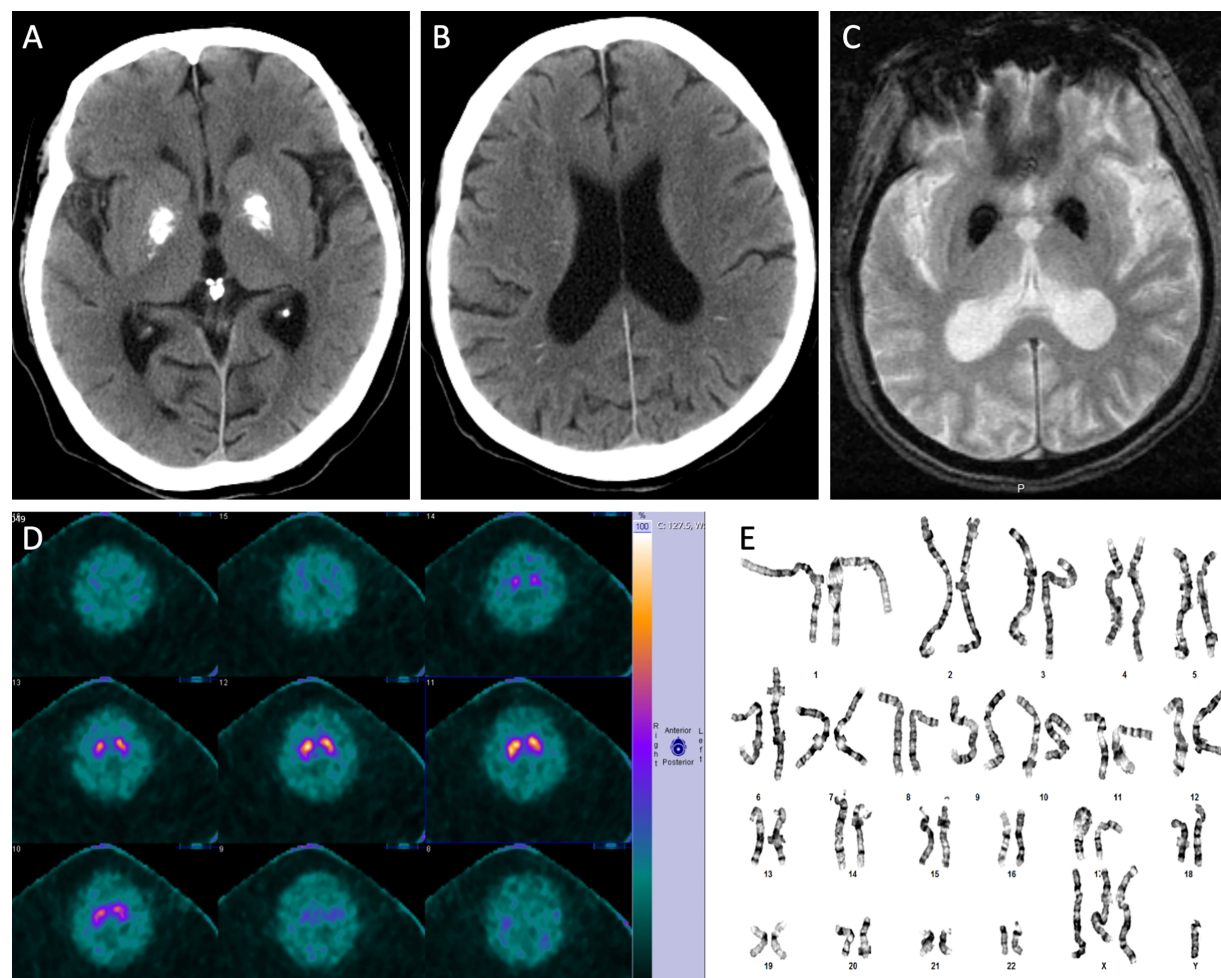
(A, B) Head computed tomography: bilateral globus pallidus calcifications and prominent sylvian fissures suggestive of brain atrophy and small linear corona radiata calcifications. (C) Brain magnetic resonance imaging: bilateral decreased T2* (gradient echo) signal in the globus pallidus. (D) DaTSCAN: normal. (E) Karyogram from GTL (G band by trypsin using Leishman Giemsa) banded metaphases: 48,XXXY karyogram.
